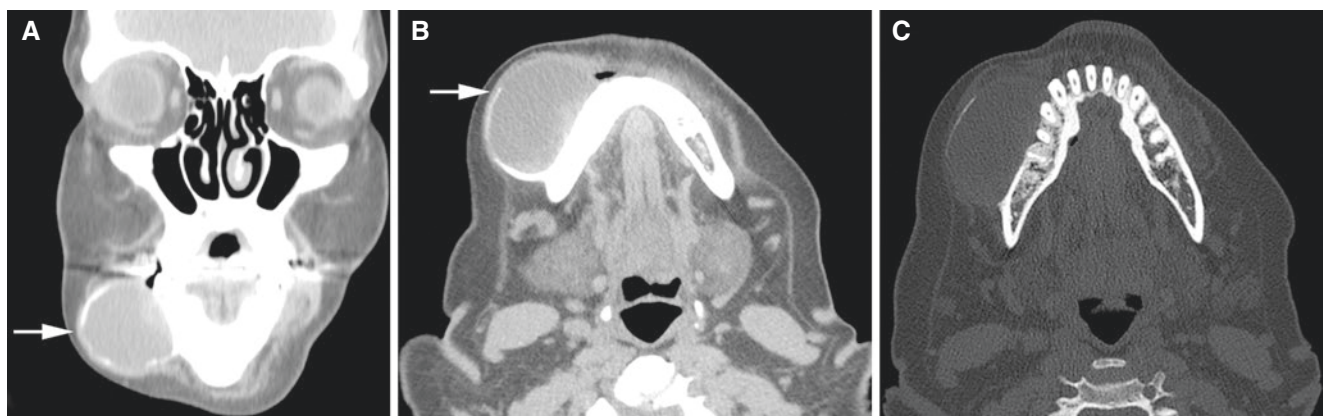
Ameloblastoma, extraosseous, mandible; 51-year-old female with right mandibular fluctuant swelling. (A) Coronal and (B) axial (soft-tissue window) CT images show buccally expanding lesion
